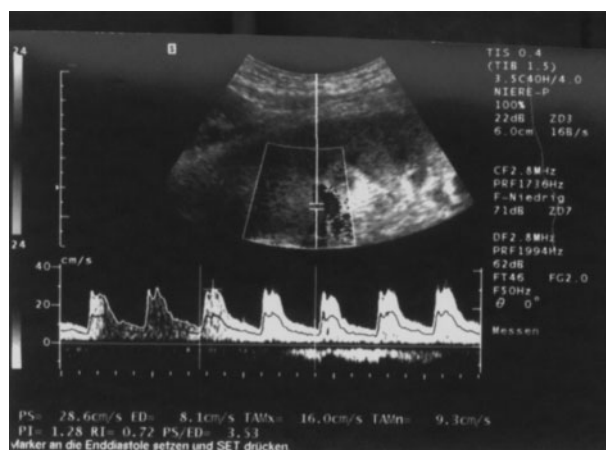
Routine Doppler-sonographic findings on day 4 after transplantation.
